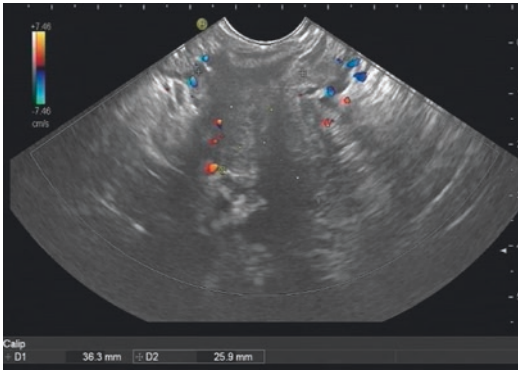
Vessels around a lesion. Color Doppler identifies vessels near the target lesion, especially those in the tract of the needle toward the target lesion. A pulsative Doppler helps differentiating an artery (high speed, pulsative/spiky flow) from a vein (low speed, Doppler with waves, no spikes)
